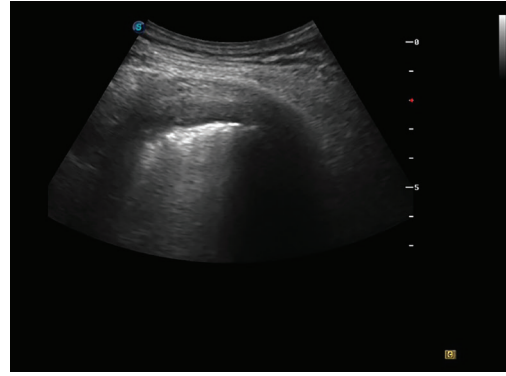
Appearance of thickened pleura on thoracic ultrasonography
